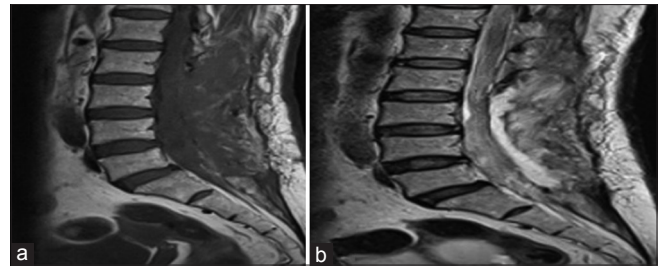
Magnetic resonance imaging L-S spine (postoperative scans): (a) T1W: Sagittal scan showing significant resolution of the preoperative lesion. (b) T2W: Sagittal scan also showing significant resolution of the preoperative lesion
